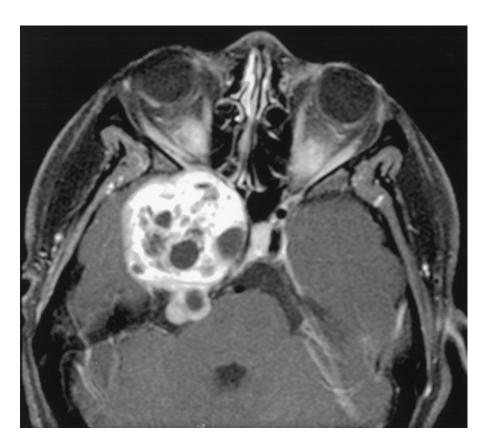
Axial post-contrast T_1 -weighted MRI reveals a dumbbell-shaped trigeminal schwannoma predominately involving the right middle fossa with extension through Meckel's cave into the posterior fossa.
